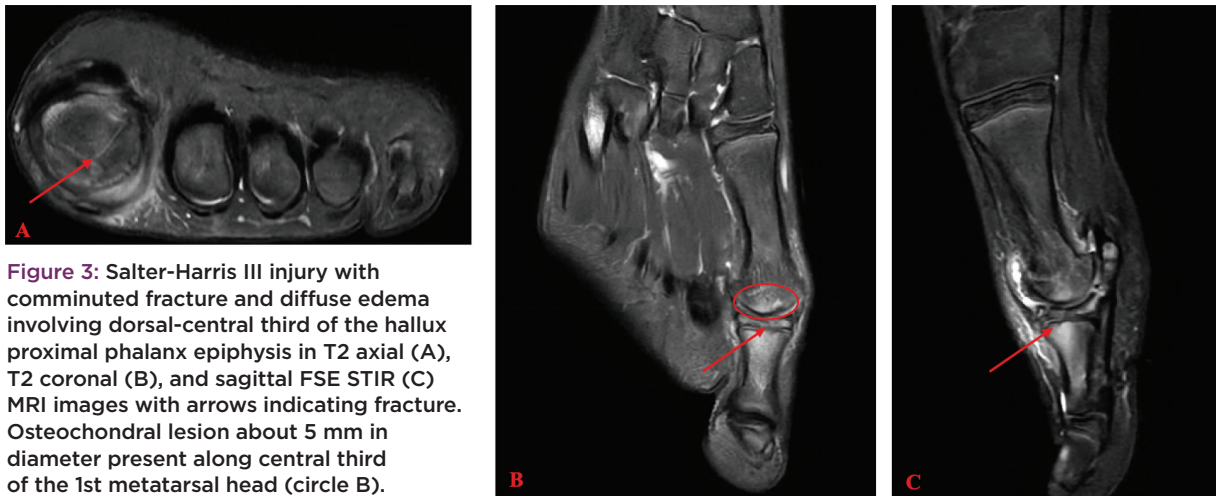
Salter-Harris III injury with comminuted fracture and diffuse edema involving dorsal-central third of the hallux proximal phalanx epiphysis in T2 axial (A), T2 coronal (B), and sagittal FSE STIR (C) MRI images with arrows indicating fracture. Osteochondral lesion about 5 mm in diameter present along central third of the 1st metatarsal head (circle B).
